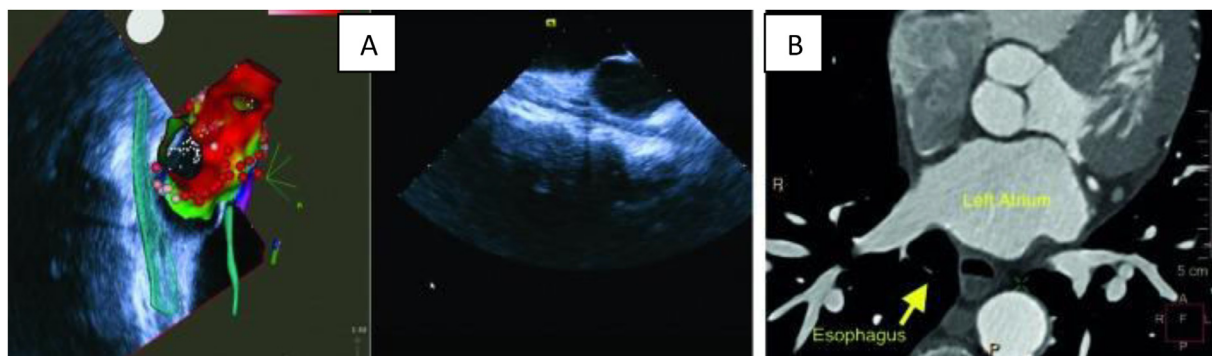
Anatomic relationship between the esophagus and the left atrium (A) Three-dimensional electroanatomic map of the left atrium and the esophagus. (B) Sagittal view of chest computed tomography showing the close proximity of the left atrium to the esophagus. Reproduced with permission from Romero et al.<sup>22</sup>
